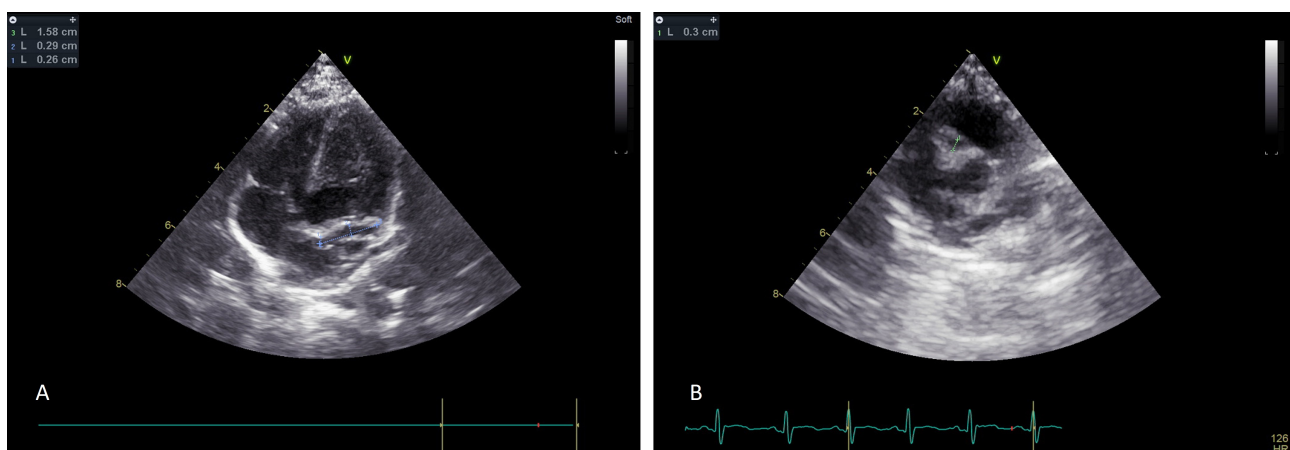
Echocardiogram on day 23. (A) Dilation of the left coronary artery and left anterior descending branch. (B) Remaining right coronary artery dilation.
